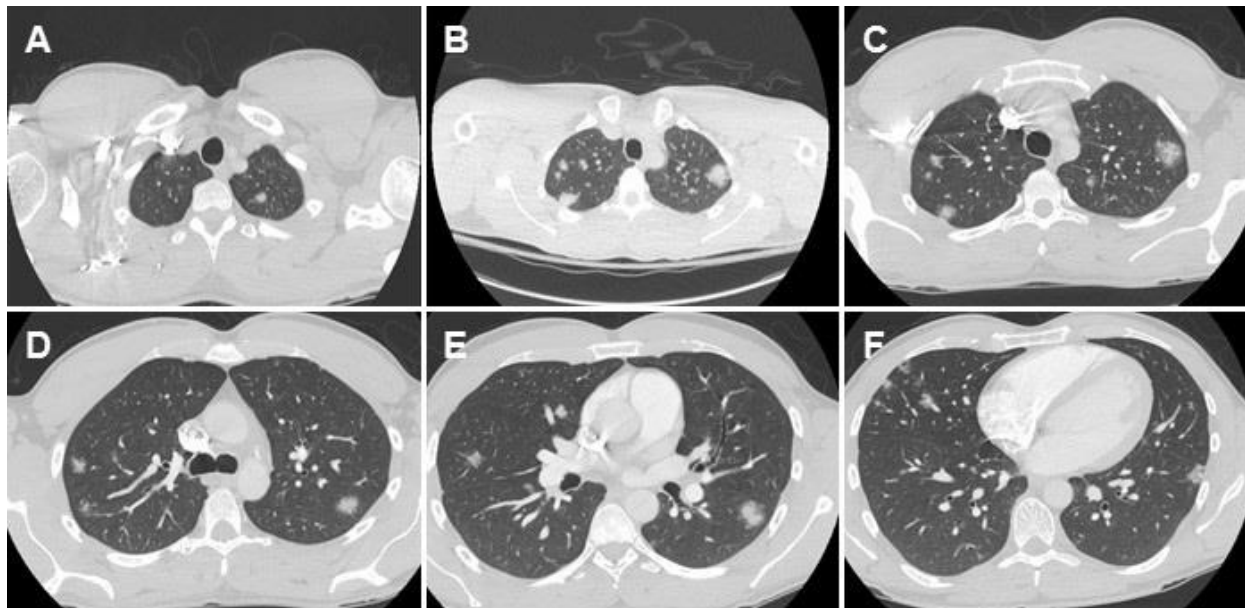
Representative images from thoracic CT scan in lung windows showing multiple pulmonary nodules. Soft tissue windows (not shown) showed a few marginally enlarged mediastinal lymph nodes.
